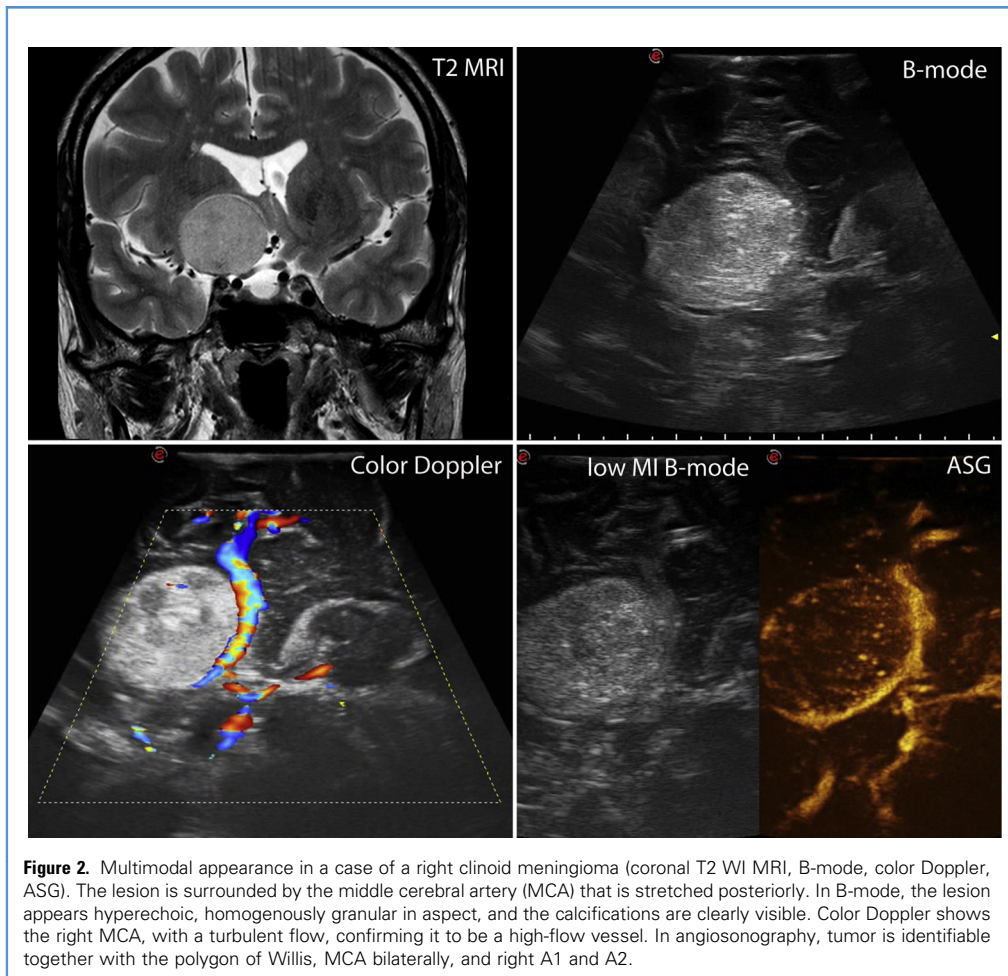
Multimodal appearance in a case of a right clinoid meningioma (coronal T2 WI MRI, B-mode, color Doppler, ASG). The lesion is surrounded by the middle cerebral artery (MCA) that is stretched posteriorly. In B-mode, the lesion appears hyperechoic, homogeneously granular in aspect, and the calcifications are clearly visible. Color Doppler shows the right MCA, with a turbulent flow, confirming it to be a high-flow vessel. In angiosonography, tumor is identifiable together with the polygon of Willis, MCA bilaterally, and right A1 and A2.
